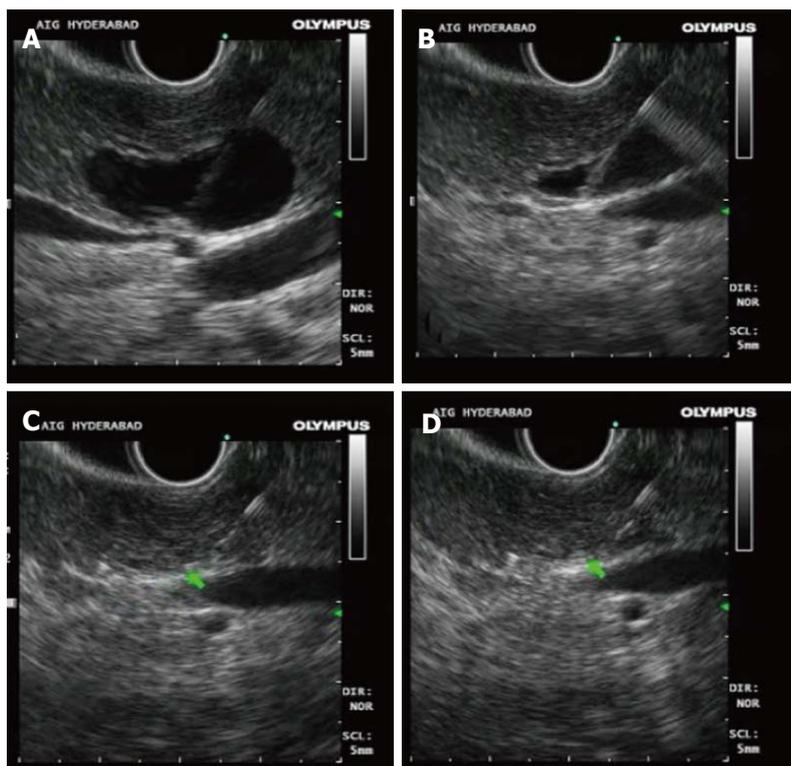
Endoscopic ultrasound pictures of radiofrequency ablation of pancreatic cyst. A: Pancreatic cyst with the biopsy needle in position; B: Aspiration of the pancreatic cyst; C and D: Complete aspiration of the cyst followed by radiofrequency ablation using the endoscopic ultrasound radiofrequency ablation catheter.
